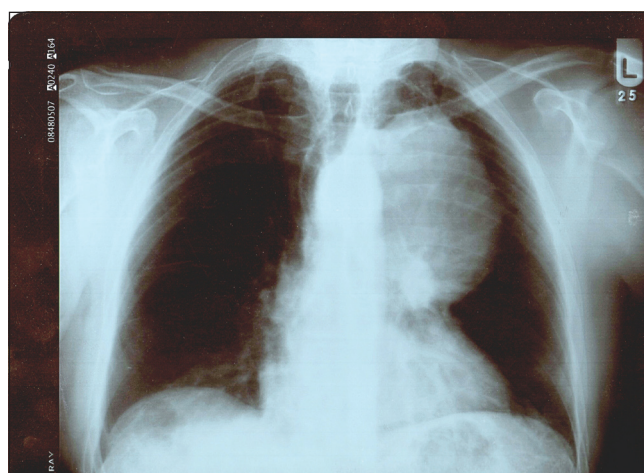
Chest radiograph demonstrating a mass abutting the mediastinum within the left hemithorax.
